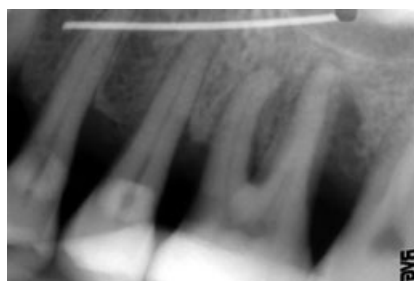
Digital radiography image at baseline.
